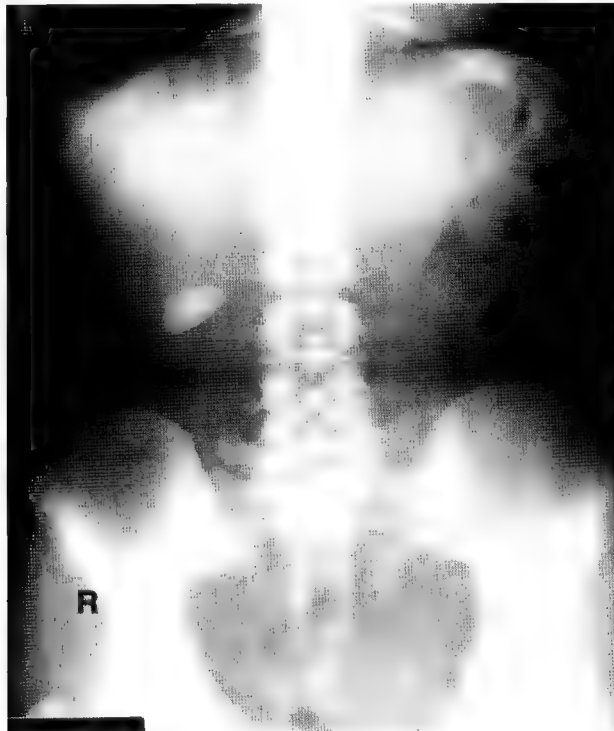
Plain abdominal X-ray of the current patient showing a radio-opaque calculus near the second and third lumbar vertebrae on the right.
